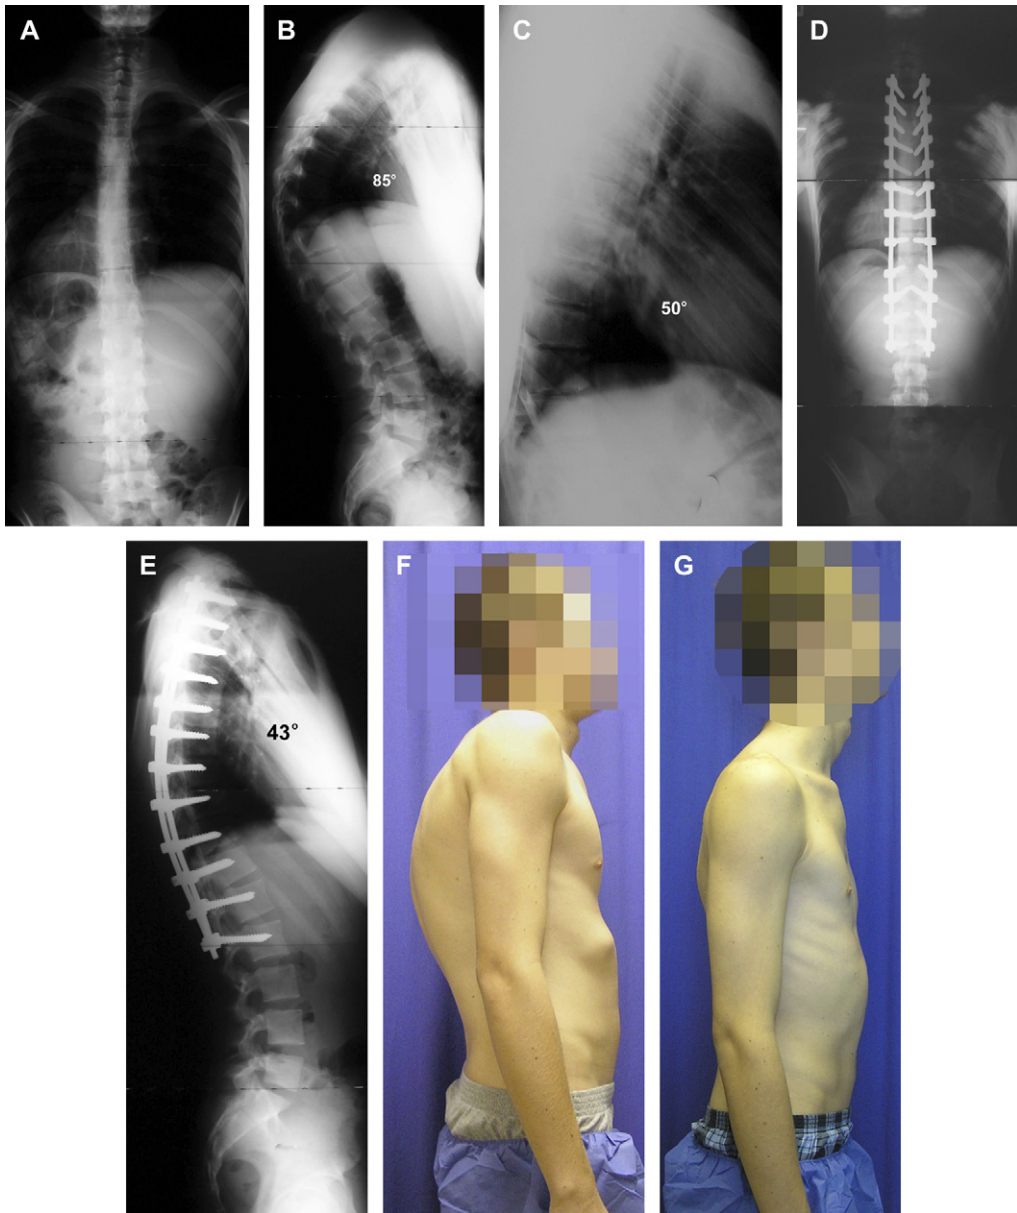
(A) Anteroposterior, (B) lateral, and (C) hyperextension radiographs demonstrate the pedicle screw construct (D, E) for Scheuermann's disease as well as (F) pre- and (G) postoperative clinical photographs.
